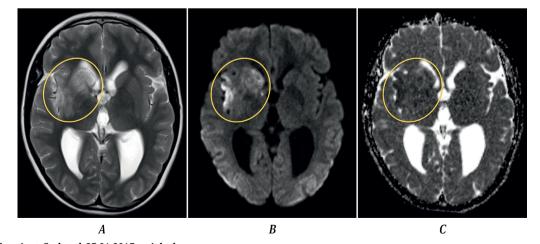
MRI of patient S. dated 27.01.2017, axial plane. A-T2-weighted imaging; B-DWI (b-1000); C-ADC map. Heterogeneous areas of increased intensity of MR signal in T2 and DWI (b-1000) sequences, with heterogeneous reduction of MR signal on ADC map ("acute" infarction), are observed in the head of the caudate nucleus, putamen, anterior limb of the internal capsule, and gray/white matter of the insular lobe in the right cerebral hemisphere.
